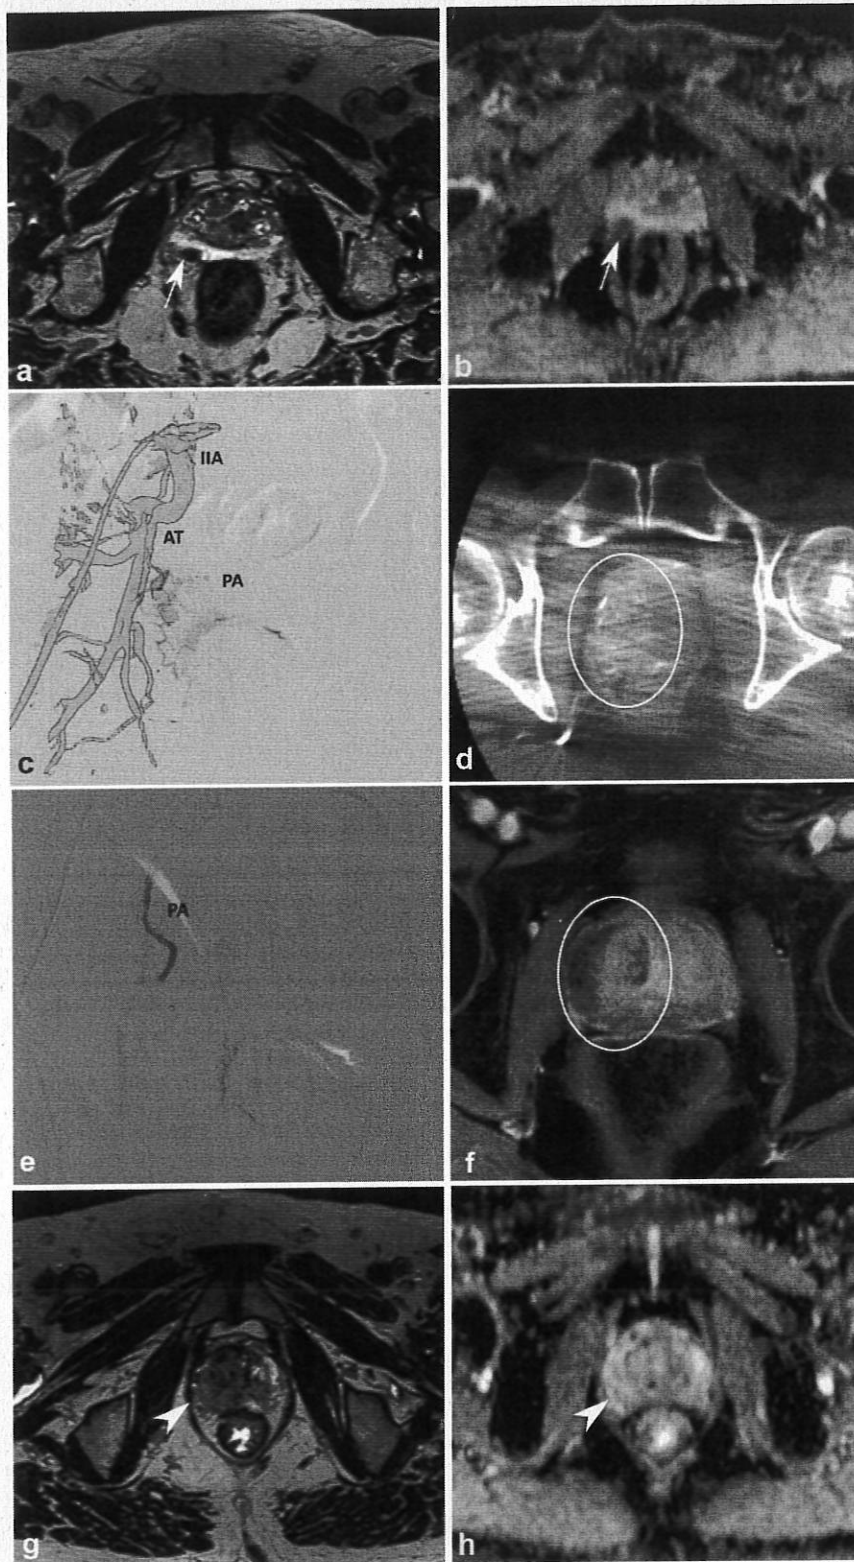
Feasibility of prostatic artery embolization: Multiparametric MR imaging of patient 6 with the target lesion (white arrow) visible in (a) 3D T2-weighted imaging and (b) apparent diffusion coefficient (ADC) map as a well-circumscribed hypointensity in the right peripheral zone, measuring 10 mm. Digital subtraction angiography with injection in the internal iliac artery (c) showed the right prostatic artery arising from the anterior trunk. The cone-beam CT angiography performed in the prostatic artery (d) confirmed the tumor-feeding artery, with the vascularization of the right prostatic lobe (white circle). Successful embolization was defined by the complete stasis of flow in the prostatic artery in the post embolization angiography (e). Dynamic contrast-enhanced MR imaging at 15 days (f) confirmed partial and heterogeneous ischemia of the right prostatic lobe (white circle), visible in 3D T2-weighted imaging (g) as a diffuse unilateral hypointensity (white arrow) and a heterogeneous iso intensity on the ADC map (h).
